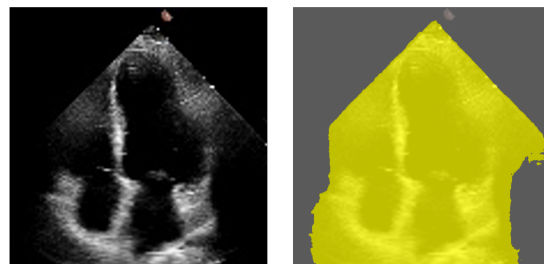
Initial segmentation without linear probing demonstrates that DINOv2 recognizes the basic echocardiogram shape but is unable to segment individual cardiac features.
